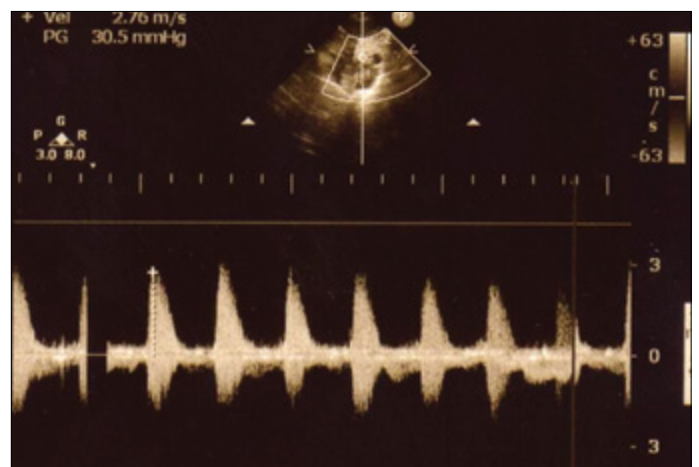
Echocardiographic image of the gradient across the aortic valve after the balloon valvuloplasty procedure
